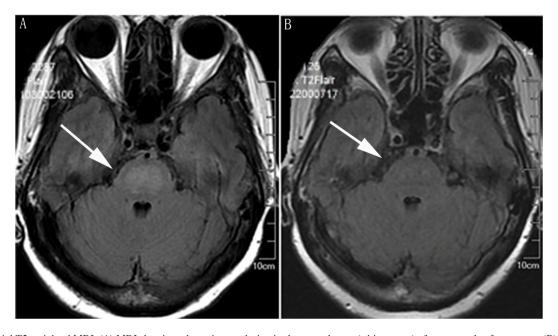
Cranial T2-weighted MRI. (A) MRI showing a hyperintense lesion in the central pons (white arrow) after one cycle of treatment. (B) MRI showing the hyperintense lesion is almost undetectable in the central pons (white arrow) after four cycles of treatment. MRI, magnetic resonance imaging.
